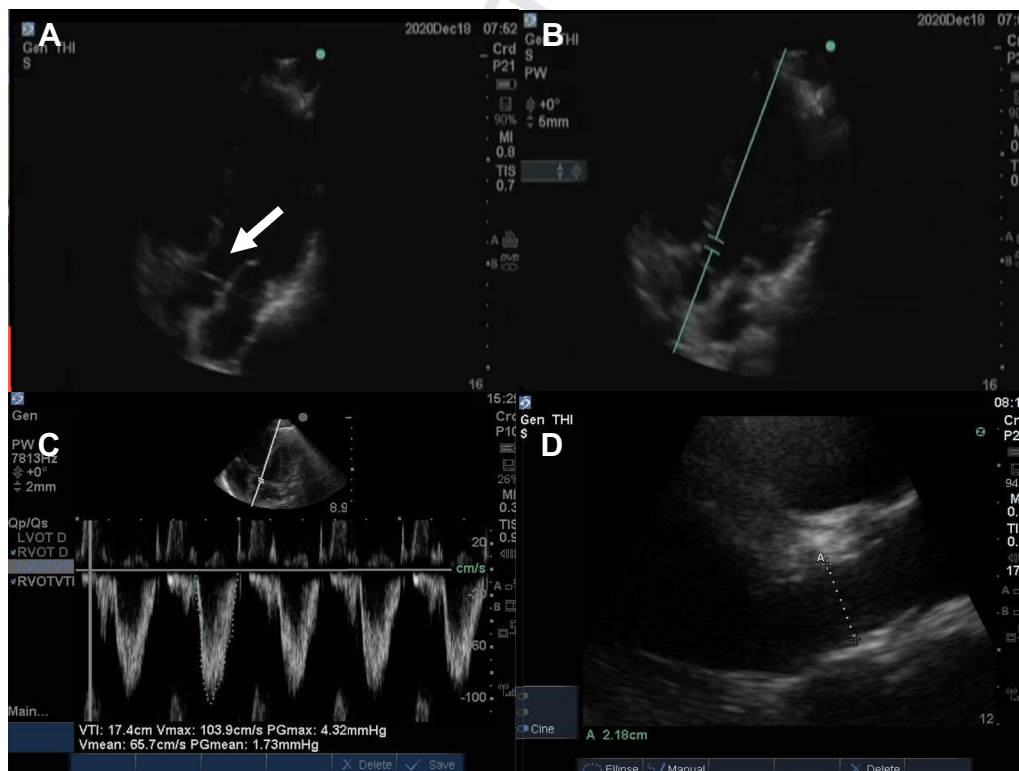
A-D, Measurement of left ventricular outflow tract (LVOT) velocity time integral to help in determining fluid responsiveness. A, Apical five-chamber view, with visualization of the LVOT (arrow). B, Pulsed wave Doppler interrogation of the LVOT. The interrogation window is placed just above the aortic valve, and the line of interrogation is positioned parallel to the long-axis of the LVOT itself. C, Measuring the area under the curve of the LVOT Doppler waveform to derive the velocity time integral (here 17.4 cm). D, Diameter of the LVOT, measured from a parasternal long-axis view (zoomed-in; here 2.18 cm).
